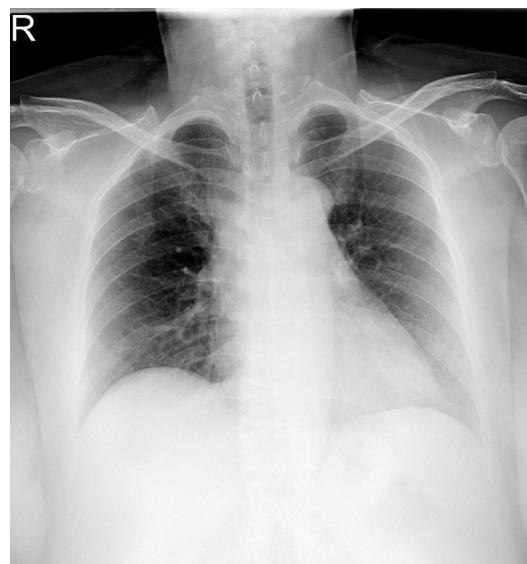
On arrival to emergency department, chest radiography showed normal heart size and no evidence of pneumonia.
